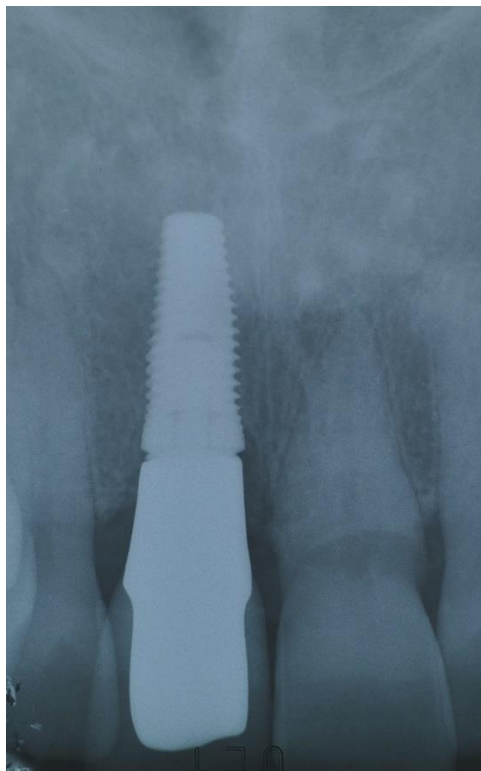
Periapical x-ray at one year follow-up.
